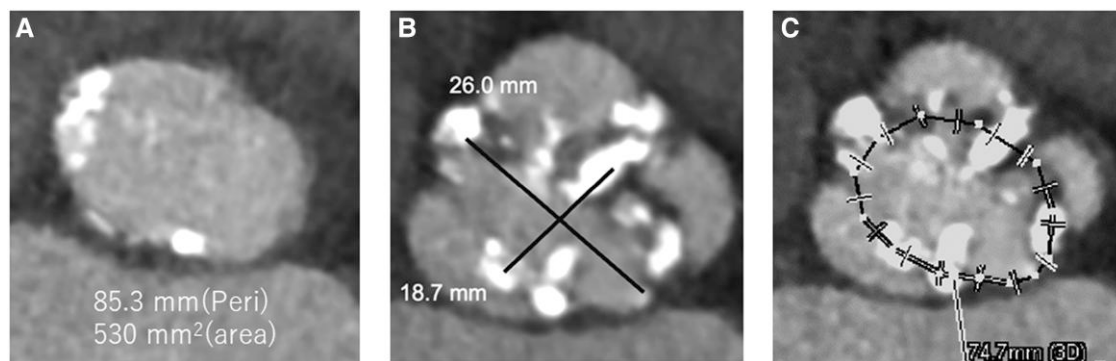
Cardiac computed tomography before the procedure. (A) Aortic annular area and perimeter measurements are 530 mm² and 85.3 mm. (B, C) Virtual aortic annular perimeter and annulus measurements are 74.7 mm and 18.7 mm × 26.0 mm, respectively.
